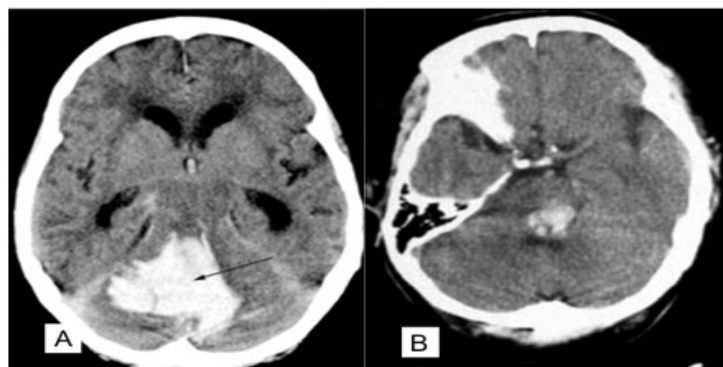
CT scan shown: A) Cerebellar hemorrhage, B) Brain stem hemorrhage.
